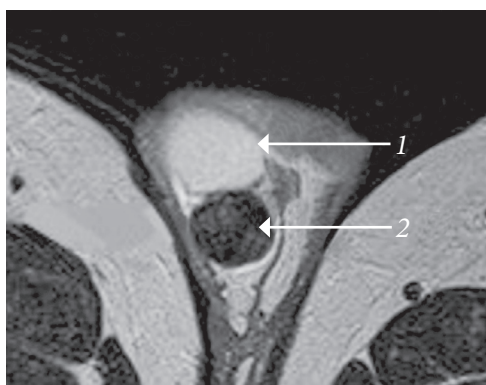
Magnetic resonance image of a neoplasm of the epididymis of the left testicle: 1 – testicle, 2 – neoplasm of the epididymis
